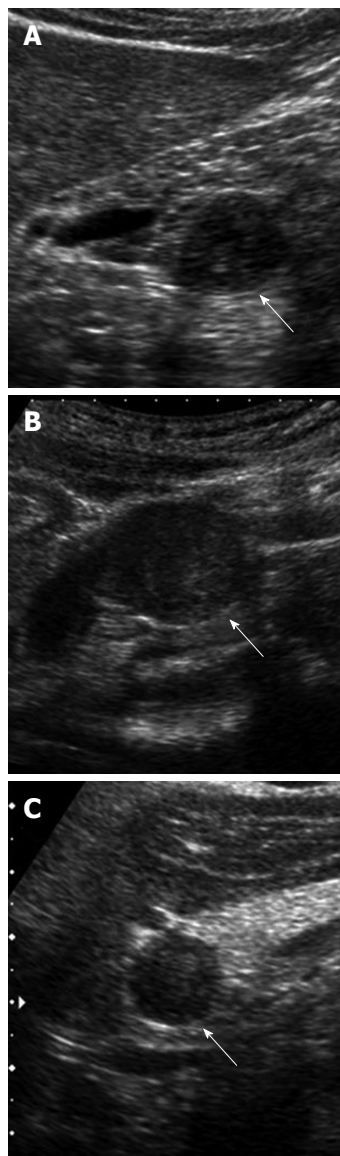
The borders of each of the tumors (arrows) are clearly defined. A: Case 1; B: Case 2; C: Case 3. Ultrasonography showed a round hypoechoic mass (arrows) with a slightly heterogeneous internal echo level.
